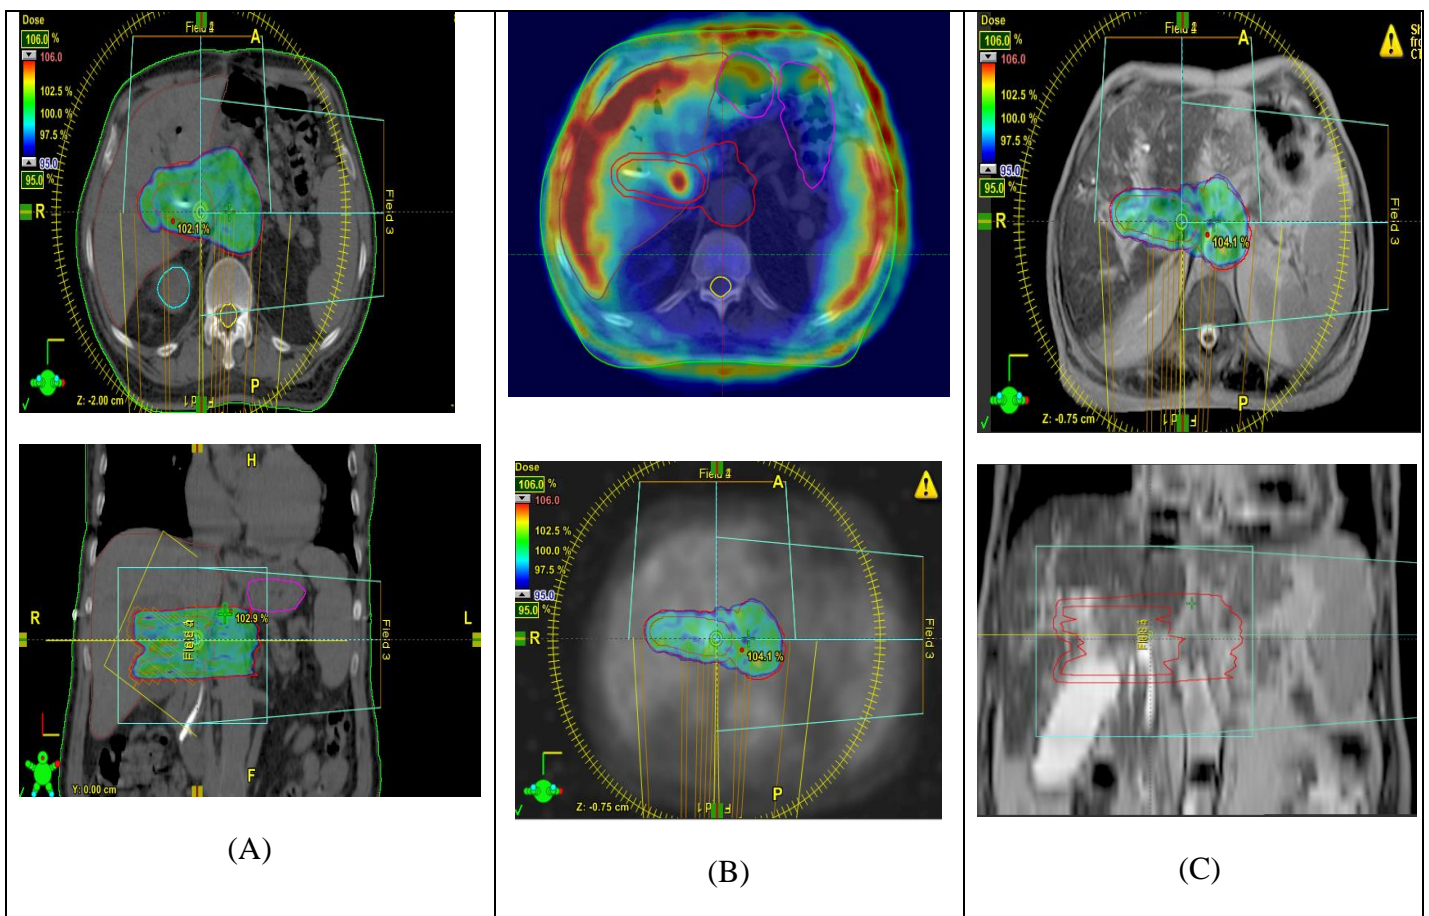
Radiation dose distribution according to radiotherapy technique. More conformal dose delivery to the main mass and tumor thrombosis with a reduced liver dose is achievable with VMAT technique, display distribution for CT for planning and calculation (A) PET image fusion (B) and MRI image fusion (C)
